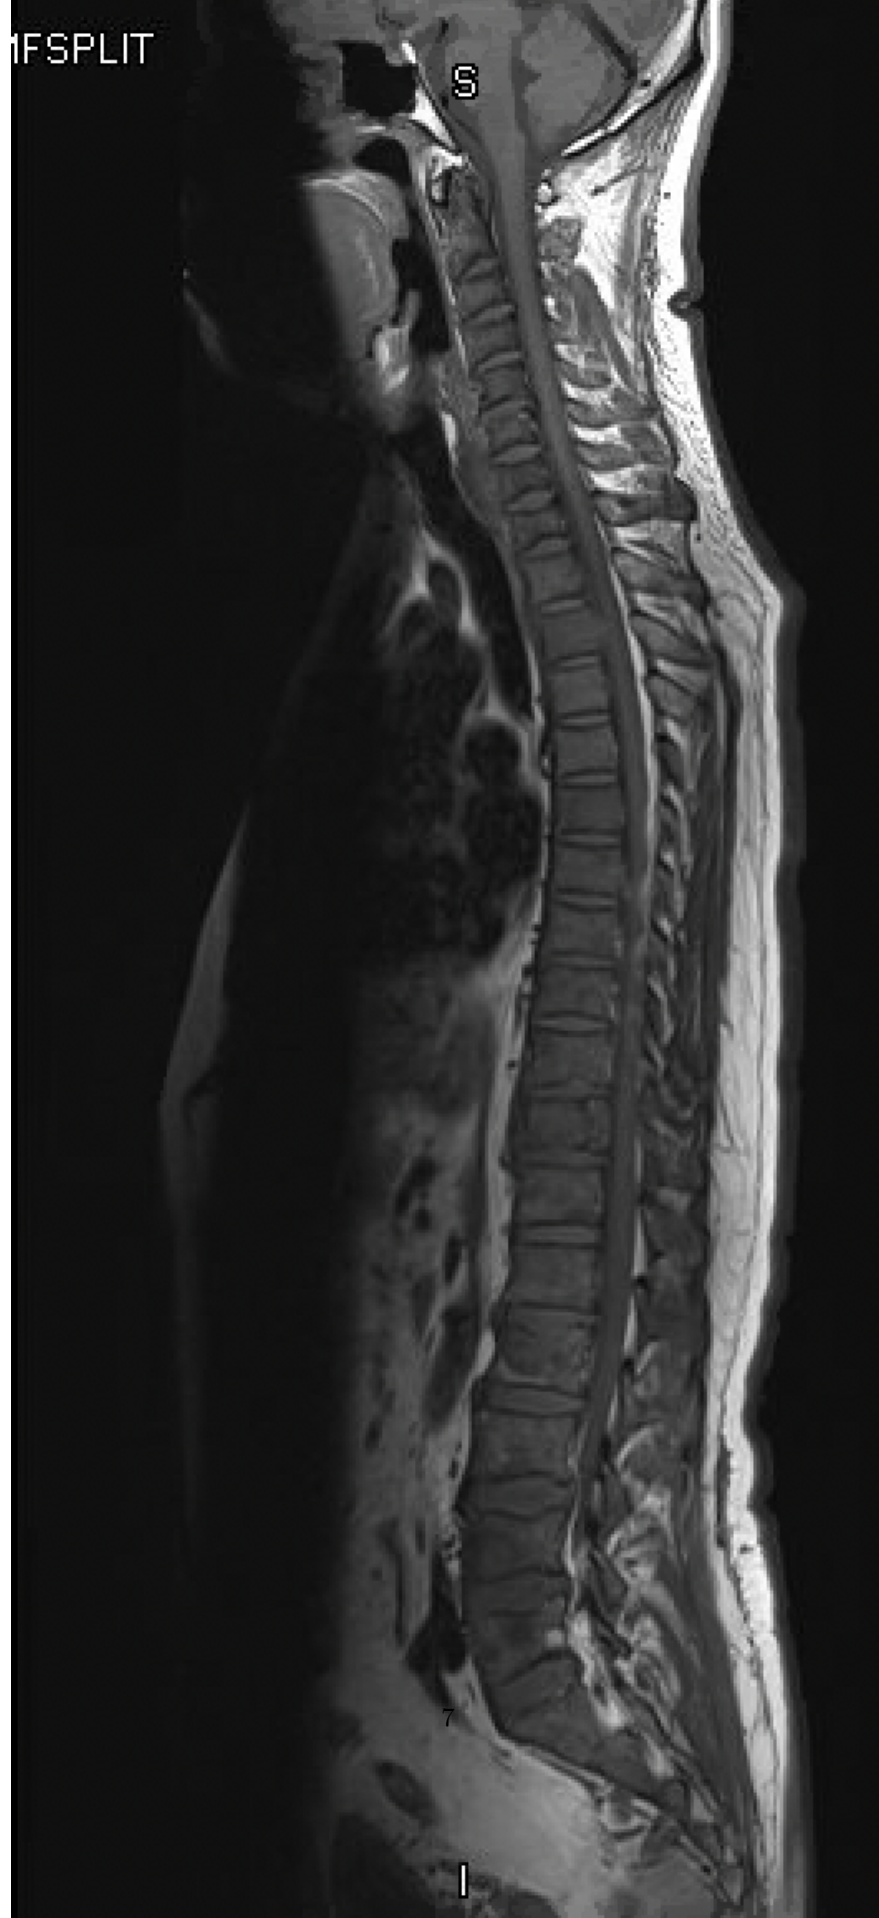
MRI of the spine showing widespread multiple variable size osteolytic metastatic lesions in the cervical, dorsal, lumbar, and sacral vertebral bodies and a few appendicular sites showing T1 low, T2/STIR bright signal with postcontrast enhancement mainly at C5, C7, T2, T3, T6, T7, T9, T11, T12, and to, L4, S1, and S2 levels.
